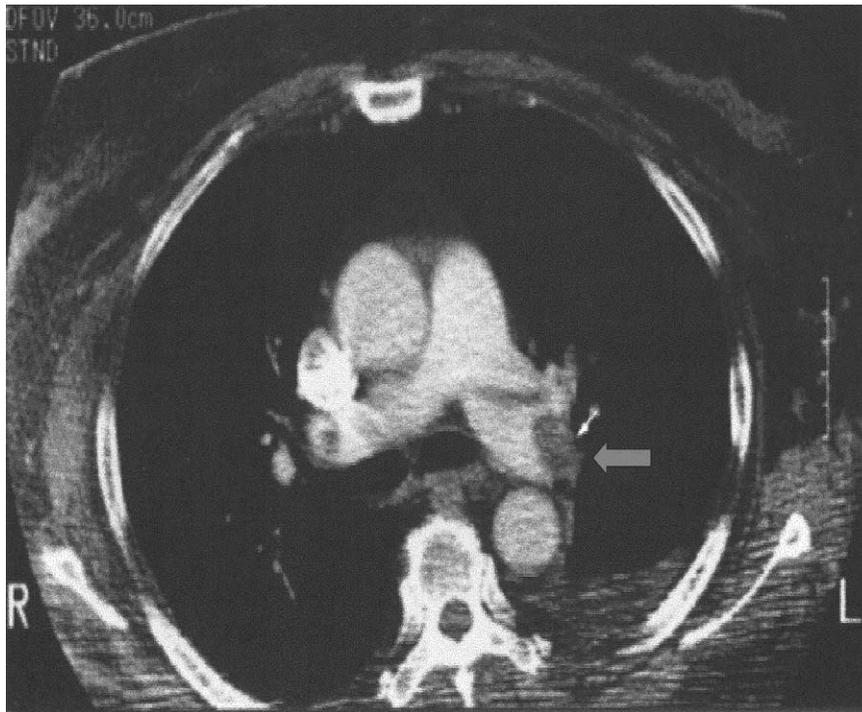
Spiral computed tomographic pulmonary arteriography has demonstrated a high rate of sensitivity and specificity in detecting pulmonary embolism (*arrow*).
